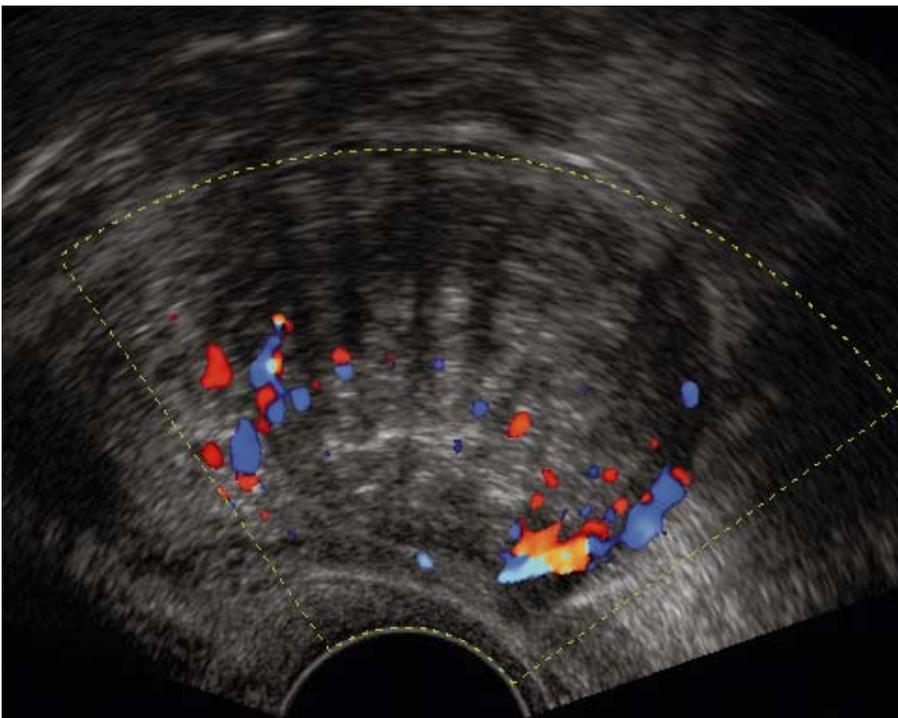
Transvaginal ultrasound of leiomyoma. Transvaginal color-coded duplex ultrasound demonstrates the perifibroid plexus vessels surrounding the leiomyoma
